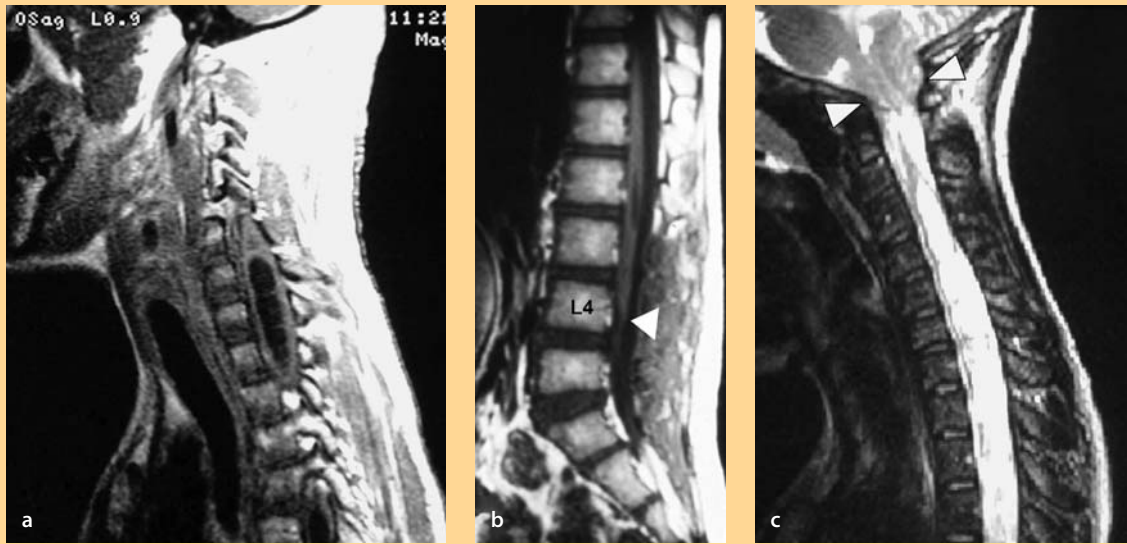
MRI identifies common associated intramedullary disorders
